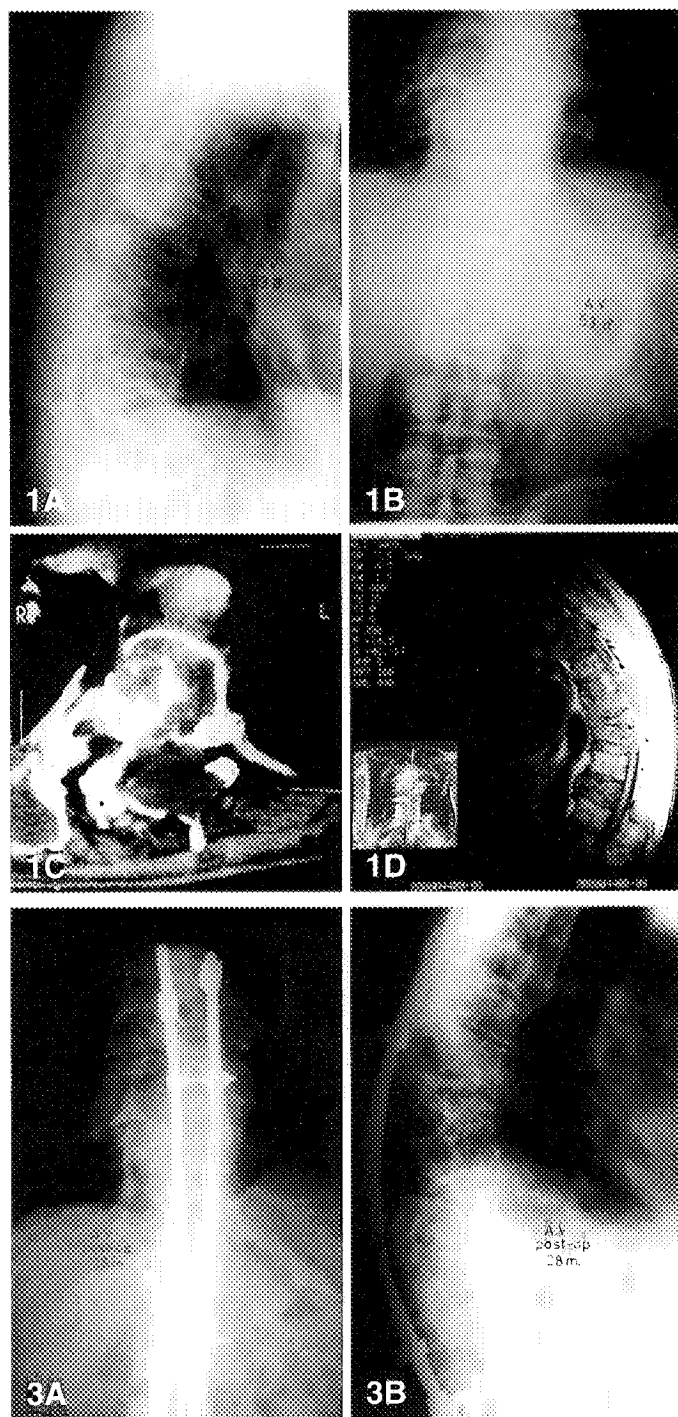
A, B Anteroposterior and lateral roentgenograms of the thoracolumbar spine show expanding lytic irregular lesions, collapse of the vertebral bodies, and kyphosis. C Computerized axial tomogram of the seventh thoracic vertebra. Note the involvement of the body, pedicle, lamina, and the right rib. D Magnetic resonance imaging demonstrates compressed spinal cord between T7 and T10
